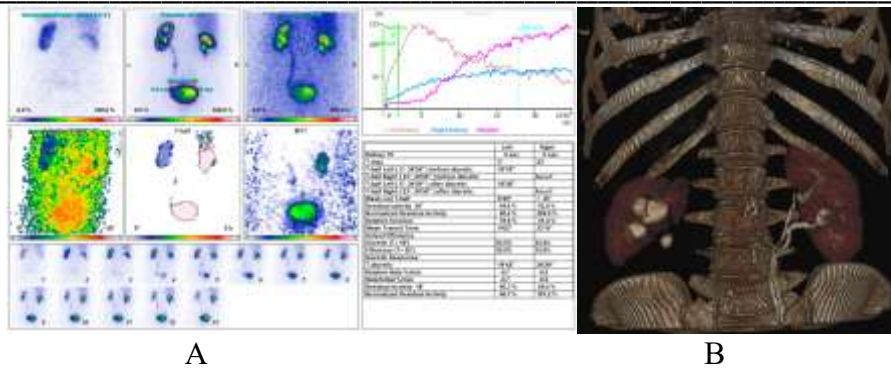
A) Examination of kidney function with Tc 99m MAG isotope 3 Dose 2 mCi. Relative functional involvement of the kidneys: Left kidney - 78.6%. Right kidney - 21.4%. Relative functional involvement of the kidneys: Left kidney - 78.6%. Right kidney - 21.4%. Scintigraphically, the location of both kidneys is normal, the contours are even, clear, the right kidney is reduced in size. The curves are asymmetrical. Radiographically: the accumulation of radiopharmaceuticals in the right kidney is slow, excretion did not occur during the study. C) Excretory phase of abdominal CT: Functional involvement of the left kidney with doubling of the pyelocaliceal system and the left ureter. The right kidney is not functioning.
